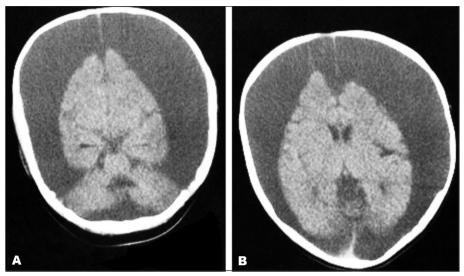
Axial non contrasted cerebral CT scan at three months, showing loss of gray-white matter differentiation. Extra-axial collection with higher attenuation than the cerebrospinal fluid, leading to parenchymal compression [A,B].
